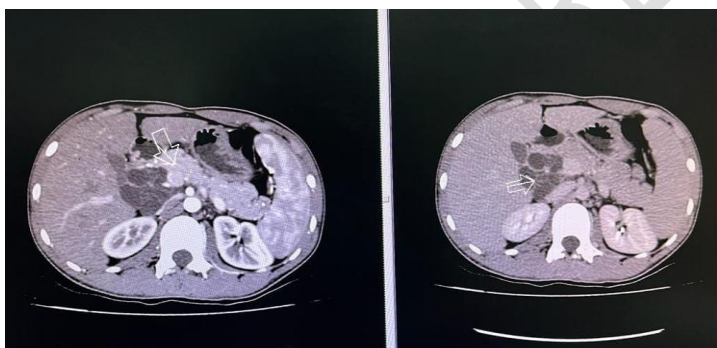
CT scan in venous phase reveal cystic lesions (white arrow) arising from the head of the pancreas.
